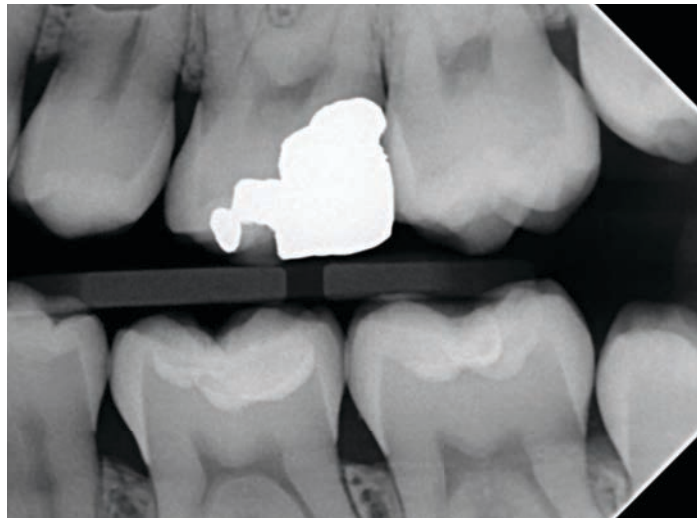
Final radiograph.
